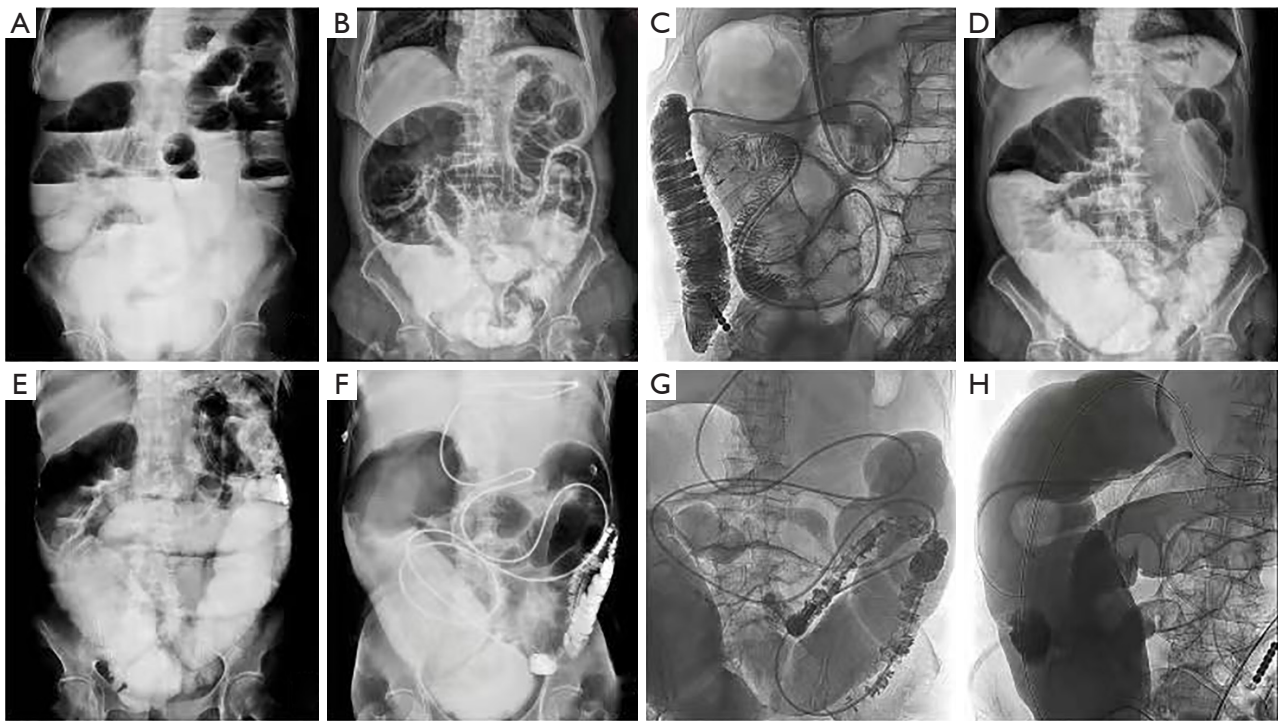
Patient 14 treatment course. (A) Multiple air-fluid level shadows arranged in steps on standing abdominal plain film 5 days before operation; (B) multiple intestinal dilatation in local small intestine on gastrointestinal radiography 4 days before operation; (C) transnasal ileus catheter insertion; (D) intestinal obstruction was not significantly relieved by re-examination of radiography 2 days after operation; (E) intestinal obstruction symptoms were slightly improved by re-examination of radiography 8 days after operation; (F) small intestinal obstruction was improved by re-examination of radiography 2 months after operation, and local dilatation of colon was obvious; (G) intraoperative radiography confirmed the stenosis site and obstruction range; (H) transnasal ileus catheter insertion combined with drainage and decompression.
